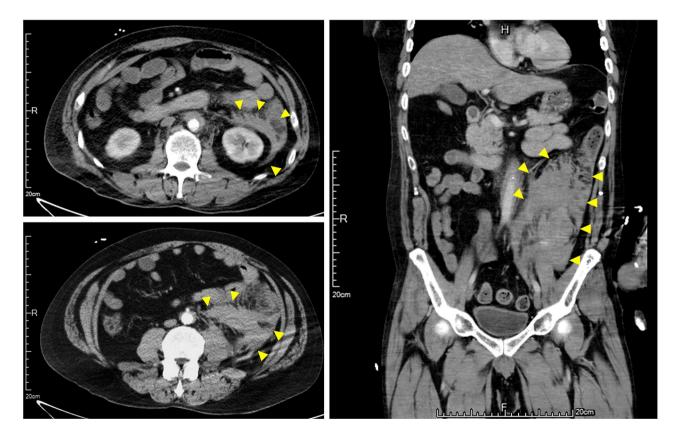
Contrast-enhanced computed tomography (CT) of the upper left and lower left abdomen. Left: axial view; right: coronal view. Left hemoretroperitoneum (mainly in the left anterior pararenal space; yellow arrowheads) and minimal hemoperitoneum were observed without definite evidence of contrast extravasation
